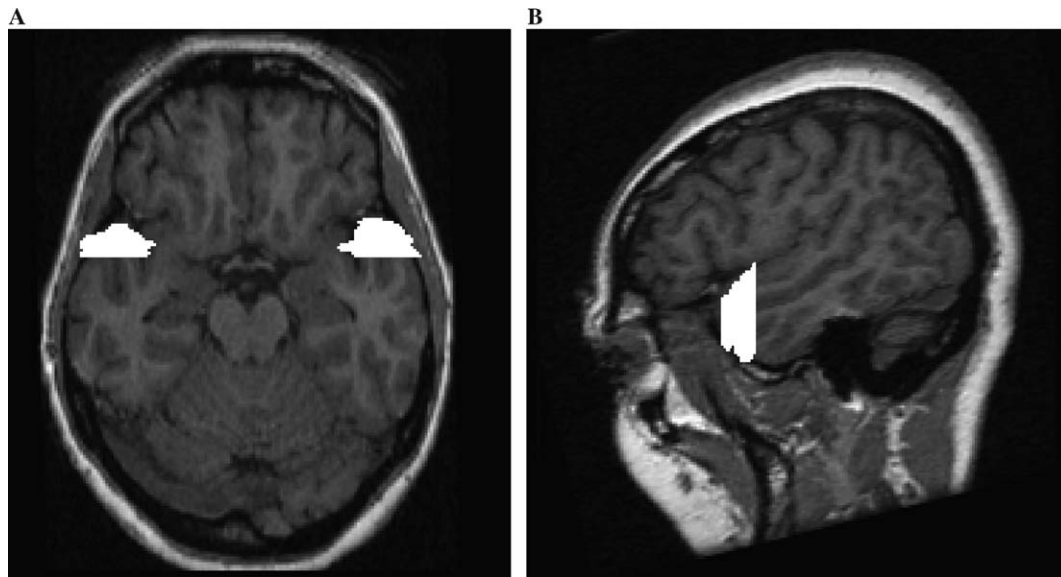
T1-weighted MRI scans demonstrating the temporal pole regions of interest (highlighted). (A) Transaxial view; (B) parasagittal view.
